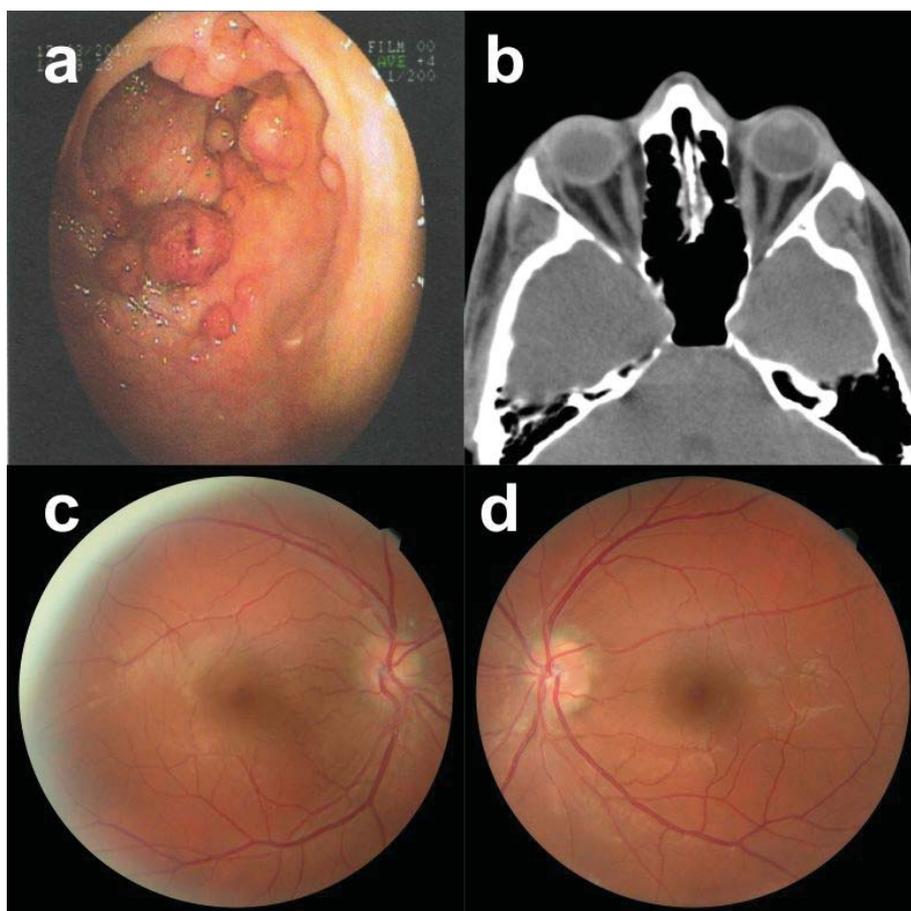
a) Colonoscopy photographs of case 1, b) Axial CT of orbits of case 1, and c. d) Color fundus photographs of case 1.
